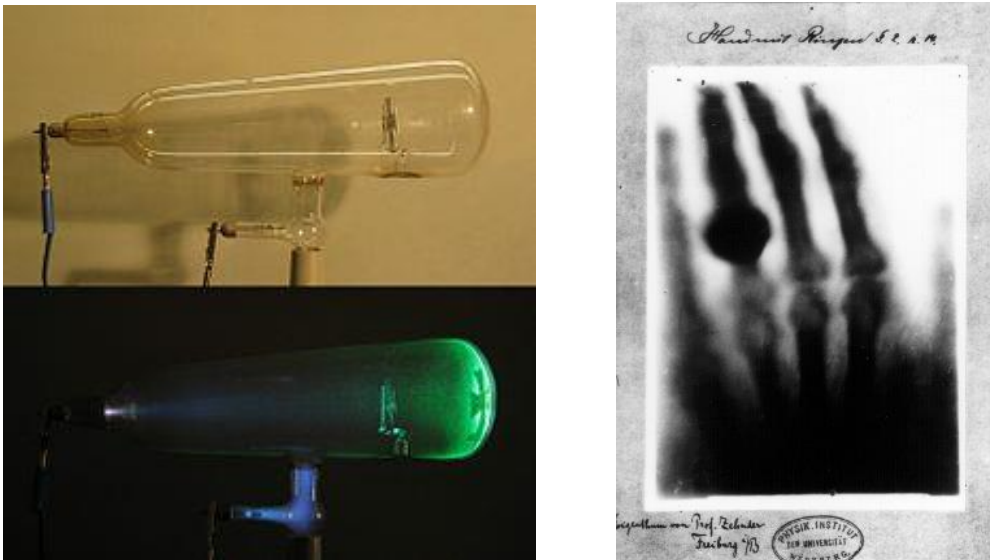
Example of Crookes tubes used by Roentgen (left); the first hand X-ray image of Roentgen's wife (right).
